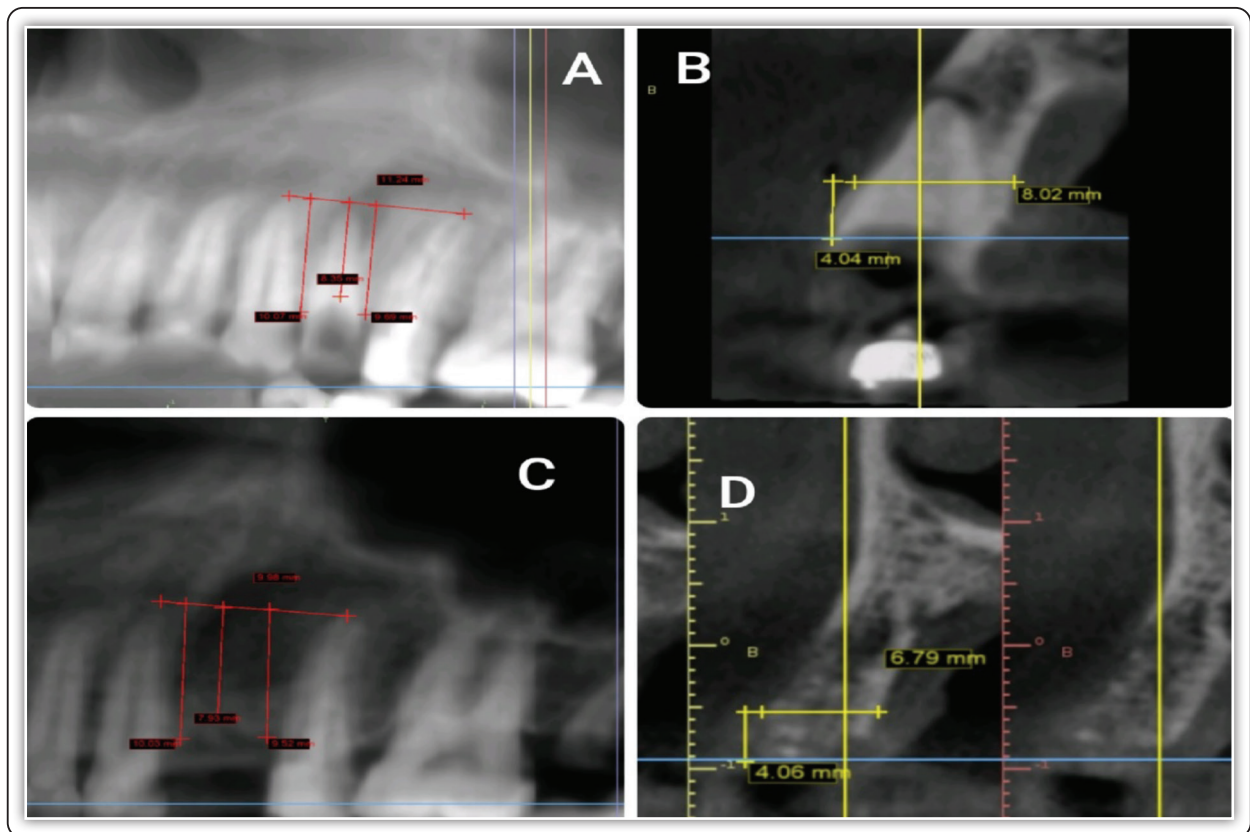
Radiographic measurements of height and width.
